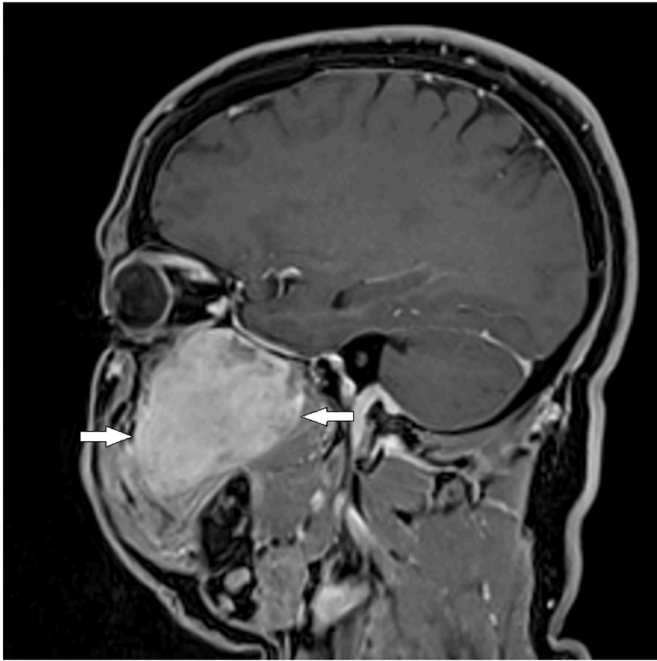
Sagittal MRI showing antero-posterior extent of the tumour (white arrows).
